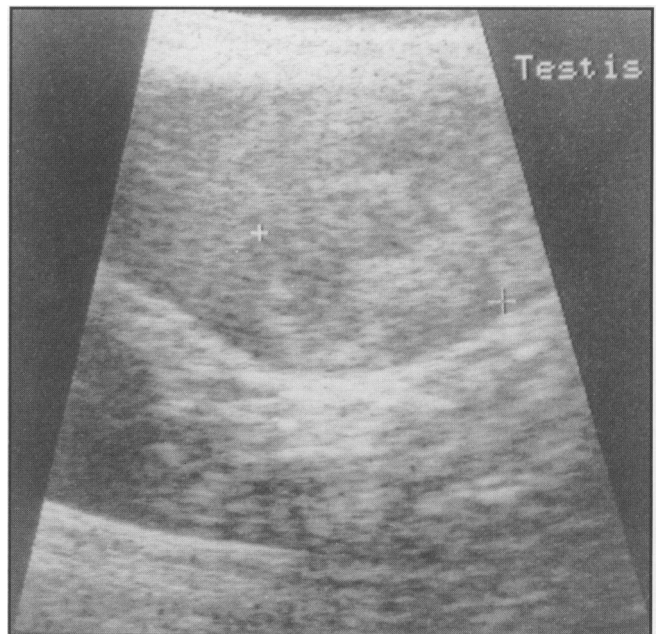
Ultrasound appearance of testicular teratoma.
